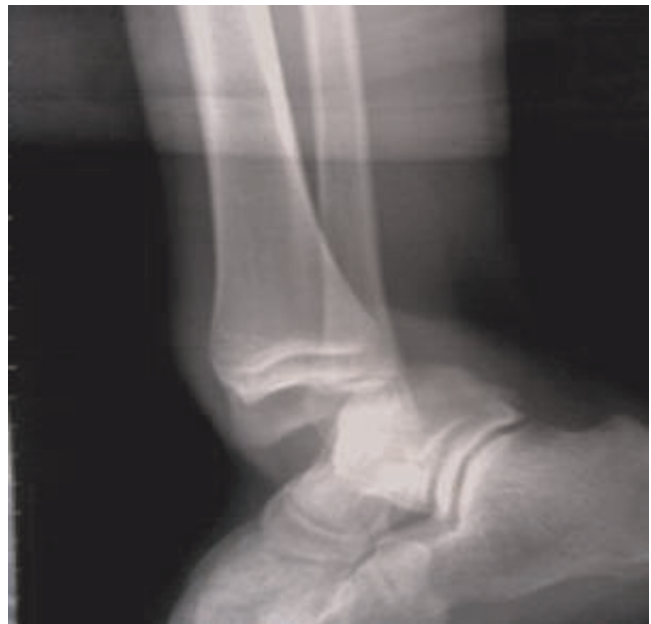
Lateral X-ray ankle showing posterior dislocation.
